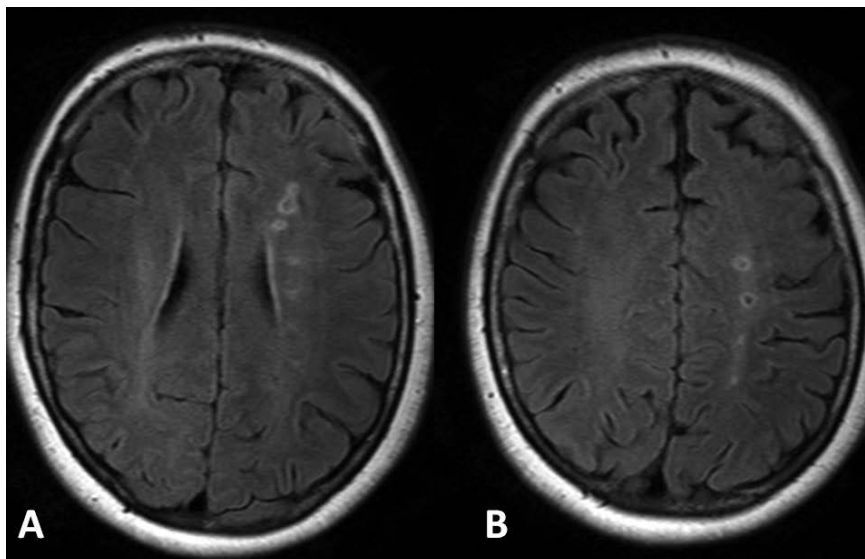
MR image of the brain of a 58-year-old woman presenting with recurrent TIAs from the left hemisphere associated with an occlusion of the left ICA. The FLAIR-sequence shows ischaemic lesions in the internal borderzone area in the corona radiata between the territories of supply of the deep and superficial perforators of the MCA (A), and in the semioval centre between the superficial perforators of the ACA and MCA (B).
